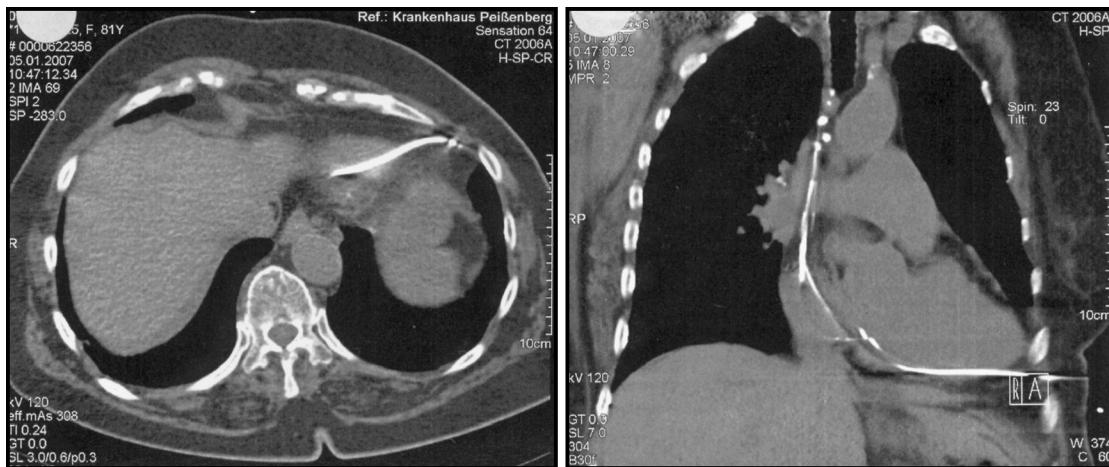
Thorax computed tomography scans showing the ventricular lead perforating the right ventricle and the pericardium (left) and the lead's tip in an intercostal space (right).
